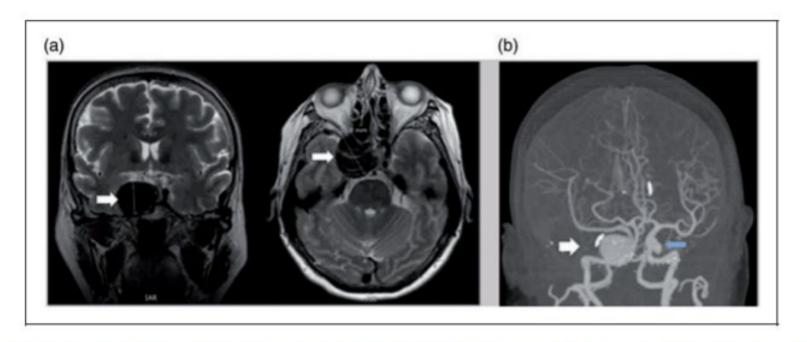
Giant internal carotid artery (ICA) aneurysm visualized on neuroimaging. The white arrows highlight various views of the partially thrombosed giant aneurysm arising from the right cavernous ICA, which measured $3.4 \times 3.1 \times 2.6$ cm, on both magnetic resonance images (a) and computed tomography angiography (b). There was also a 2 mm aneurysm projecting posteriorly from the left ICA terminus (blue arrow in (b)).
